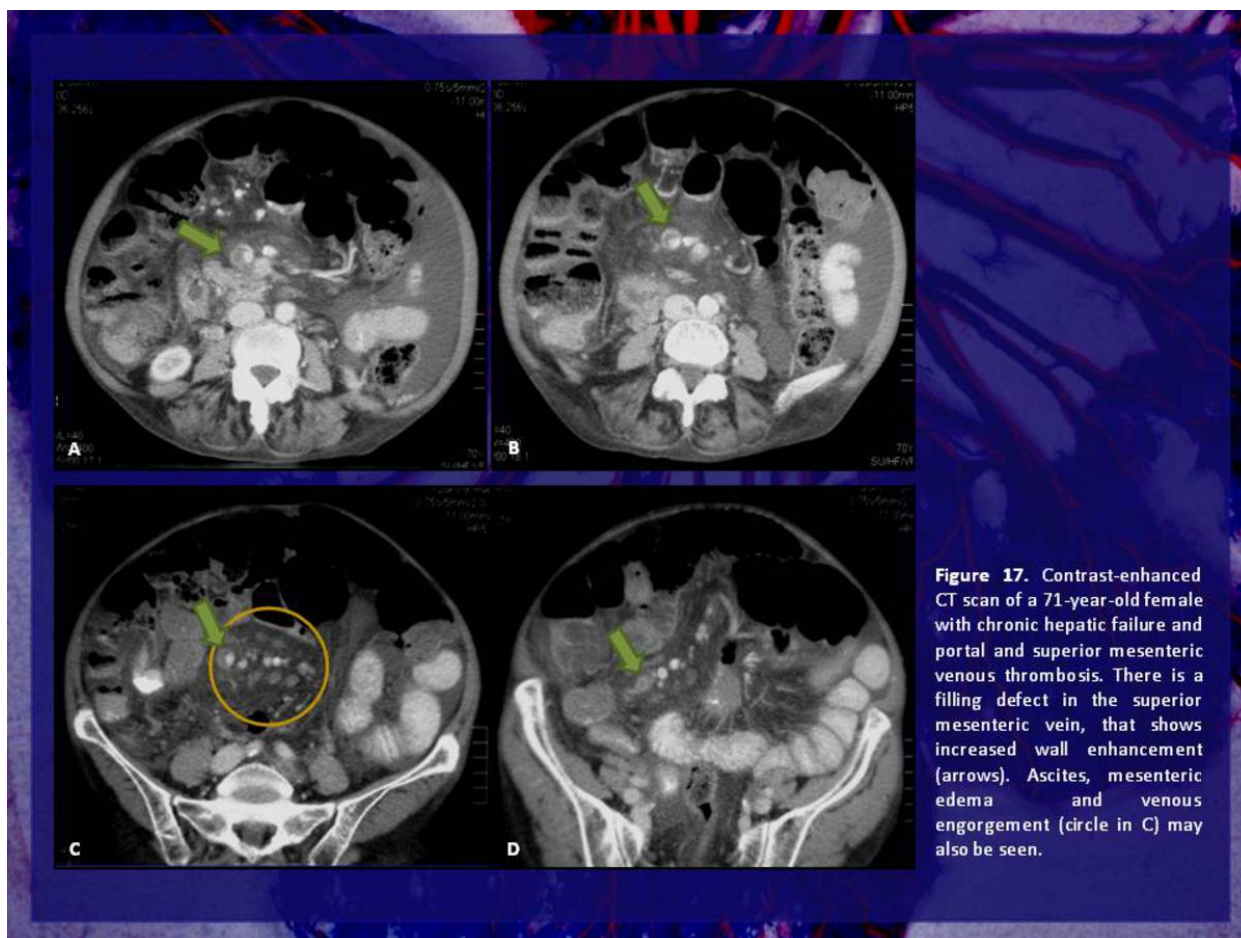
Contrast-enhanced CT scan of a 71-year-old female with chronic hepatic failure and portal and superior mesenteric venous thrombosis. There is a filling defect in the superior mesenteric vein, that shows increased wall enhancement (arrows). Ascites, mesenteric edema and venous engorgement (circle in C) may also be seen.
